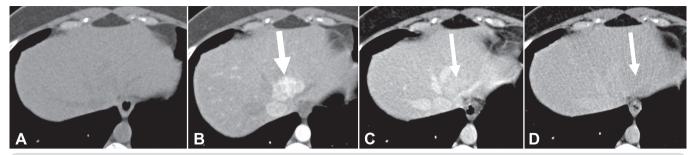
Hypervascular indeterminate nodule. Pre-contrast (A), arterial (B), portal-venous (C), and delayed (D) phases of a dynamic CT showing a large hypervascular liver nodule in segment 4, which has arterial enhancement (thick arrow) and becomes isodense to liver on the later phases. There is no sufficient specific findings to a precise diagnostic. This lesion should be considered a indeterminate nodule on CT. Further MRI (not shown) showed features suggesting adenoma and diagnosis confirmed after resection.
